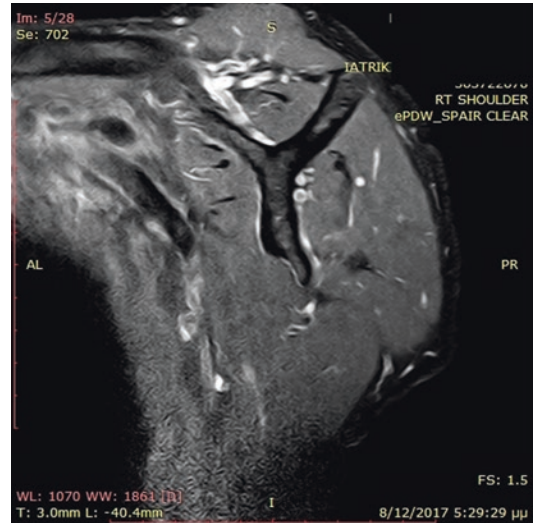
Goutallier stage II/Fuchs grade II (more muscle than fat), MRI sagittal view
